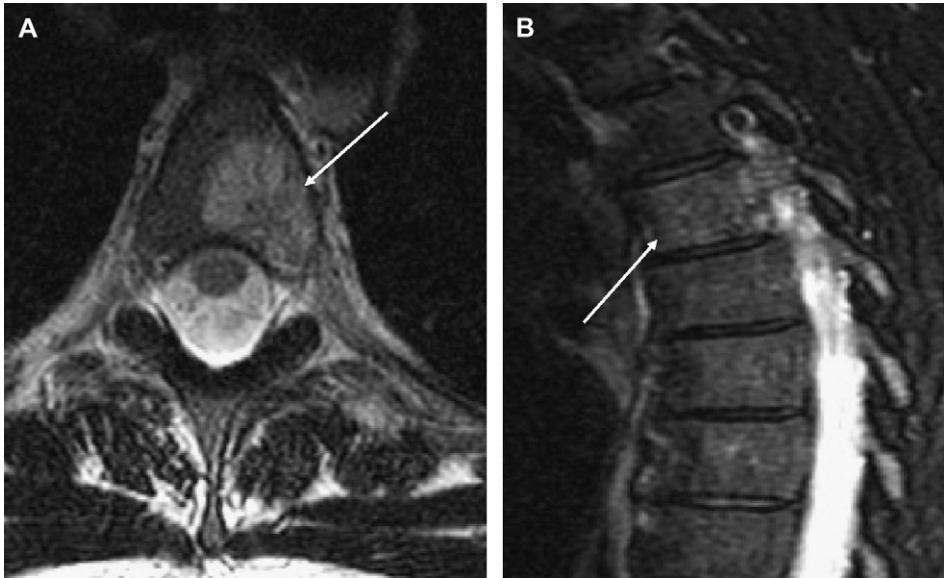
Axial fast spin echo T2-weighted MRI performed without fat saturation (*A*) shows a hemangioma (*arrow*) markedly increased in signal representing both the adipocyte, edema and vascular content. Note this hemangioma extends into the pedicle. Sagittal fast spin echo T2 sequence with fat saturation (*B*) demonstrates mild increased signal corresponding to the vascular and water content (*arrow*). This patient with severe back pain went on to have successful transarterial embolization.
